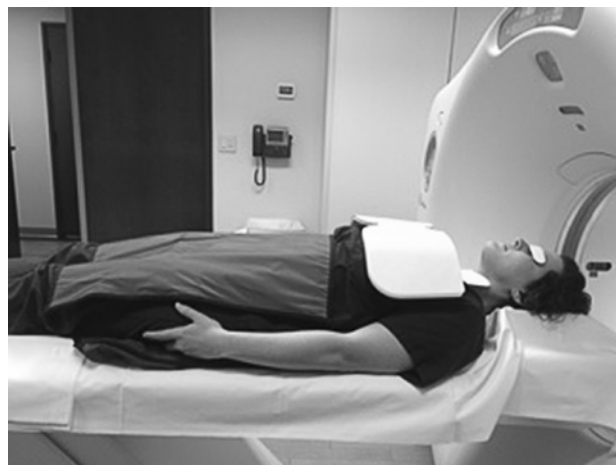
Placement of lead shielding over radiosensitive organs in computed tomography (CT) scanning with 360° beam rotation. Photo courtesy of Lydia Donaldson, BSRS, R.T.(R)(CT).
